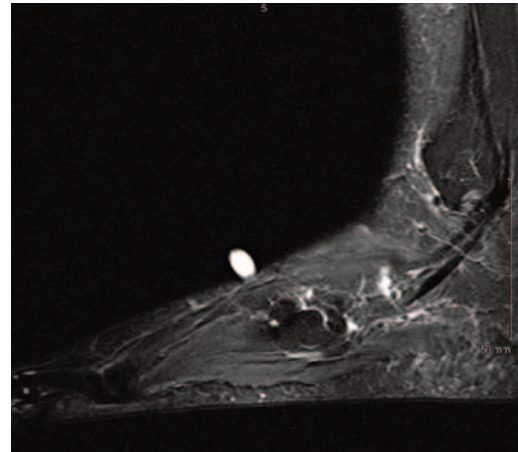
T2-weighted lateral image at 1 year.
